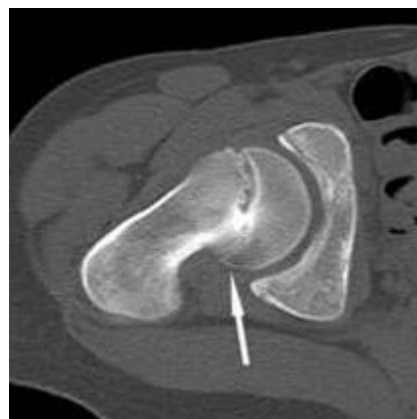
CT scan of SCFE. Chronic form. Deviation of the epiphysis of the head by the magnitude of the resorption of the dorsal, paraepiphyseal part of the cervix. Local synostosis at the level of the germ zone.
